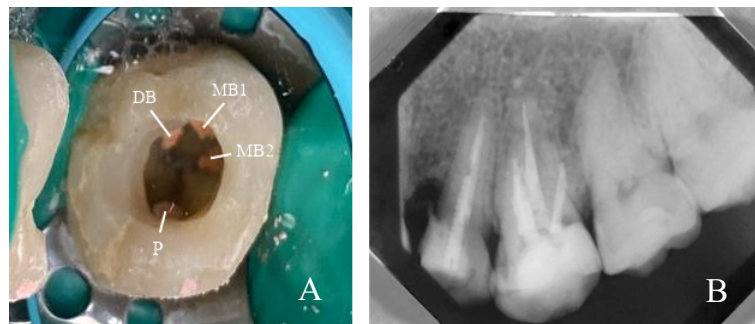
(A) Clinical view showing obturation on the mesiobuccal1 (MB1), mesiobuccal2 (MB2), distobuccal (DB), and palatal (P) canals; (B) radiographic view of obturation all the root canals.
